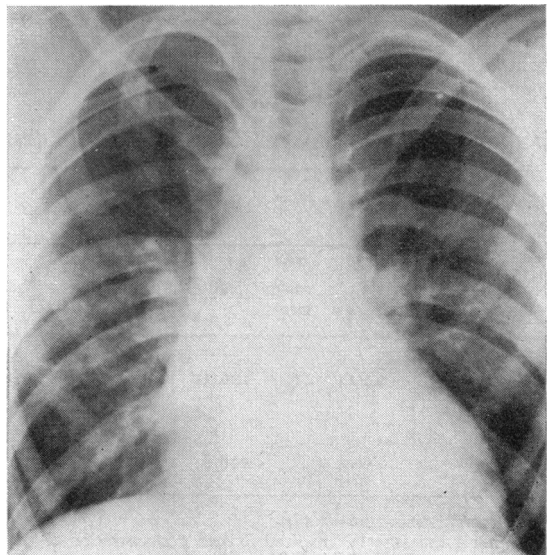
Case 1. Chest x-ray.
